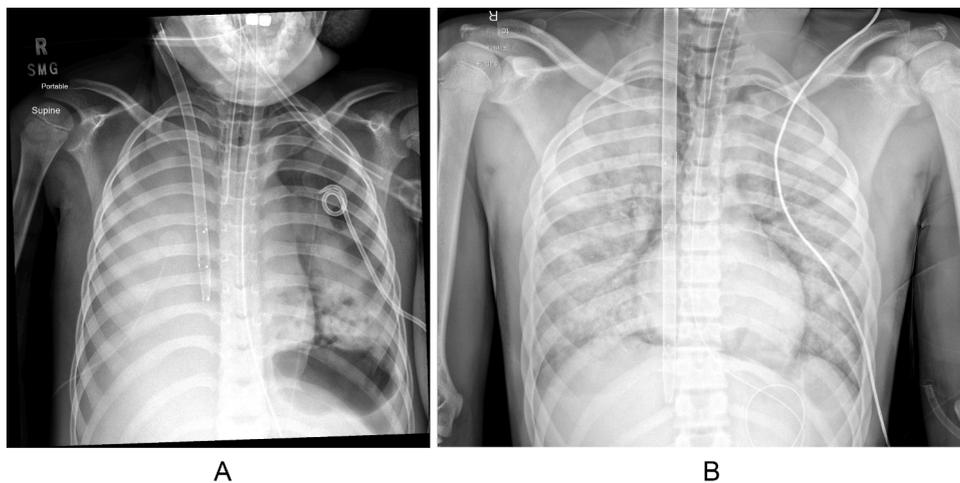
VV ECMO cannula positioning on chest Xray (A) demonstrates correct placement of dual lumen atria (RA) cannula. (B) Demonstrates correct placement of dual lumen bicaval cannula.
